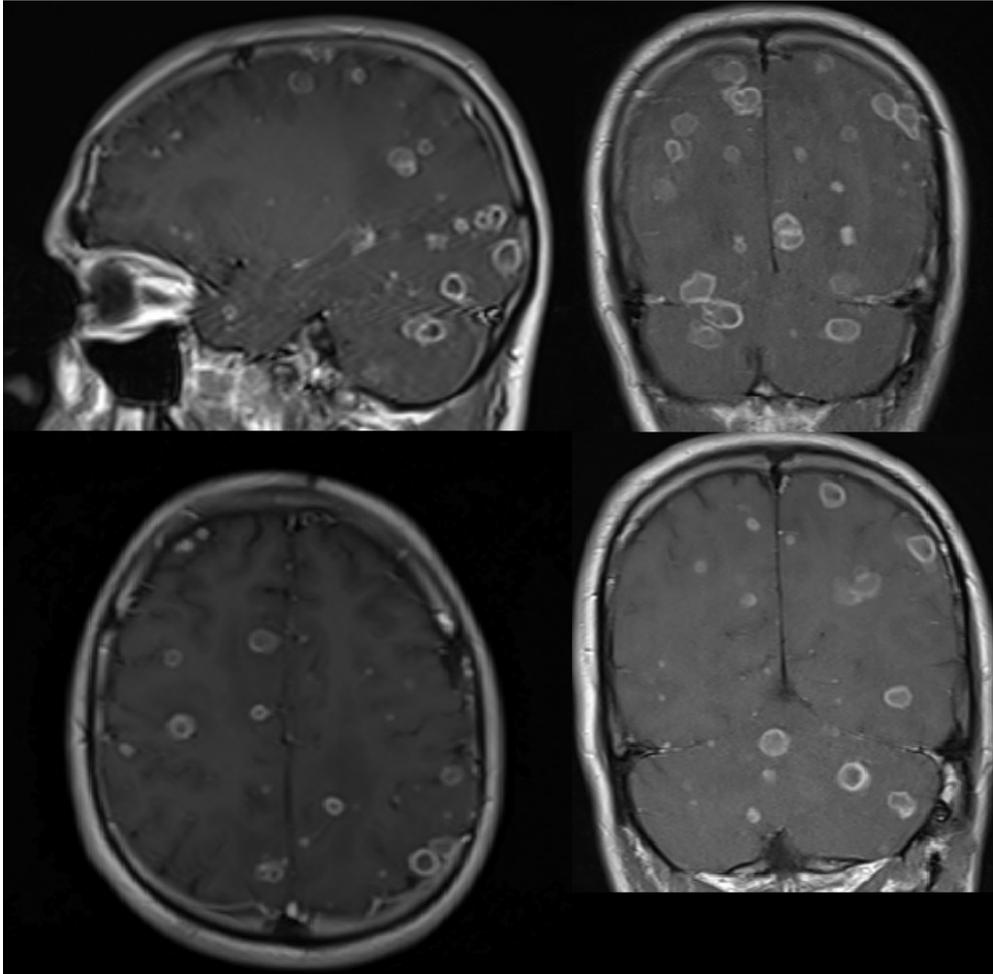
a,b,c,d. Axial (c) and coronal (a,b,d) magnetic resonance images show multiple contrast-enhanced cerebral and cerebellar lesions with generalized edema
